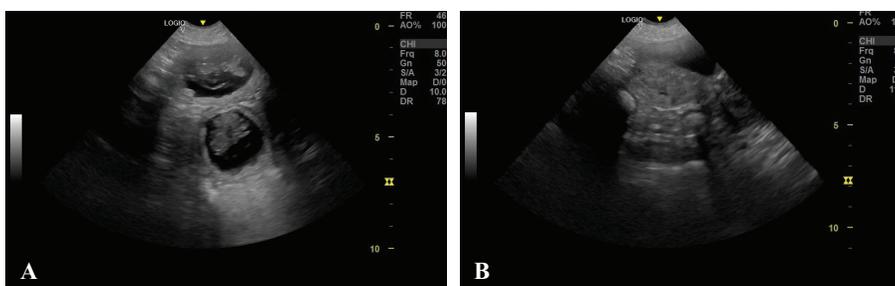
Ultrasonographic image of amniotic sacs (A) and reabsorption site (B)
